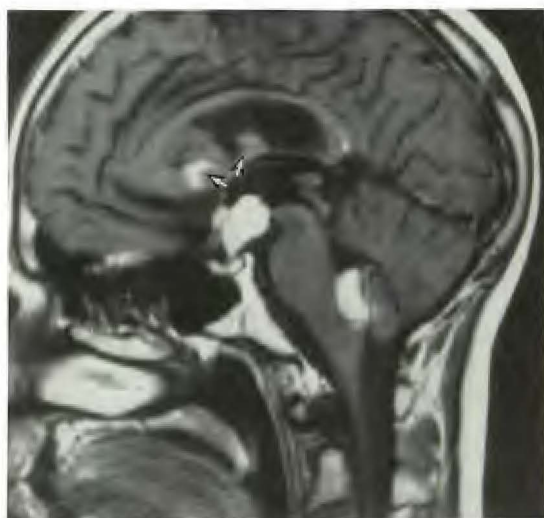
Medulloblastoma. Sagittal T1-weighted Gd-DTPA-enhanced MR image (600/20) shows marked enhancement of recurrent tumor within fourth ventricle and a large loculated leptomenigeal metastasis in suprasellar cistern infiltrating into hypothalamus. Also noted are less enhanced ependymal metastases (arrows).
